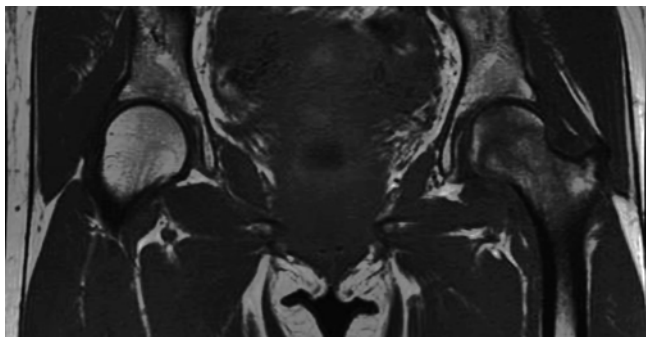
T1-weighted spin-echo image (TR/TE: 549 ms/22 ms) reveals diffuse, low-signal intensity in the left proximal femur
